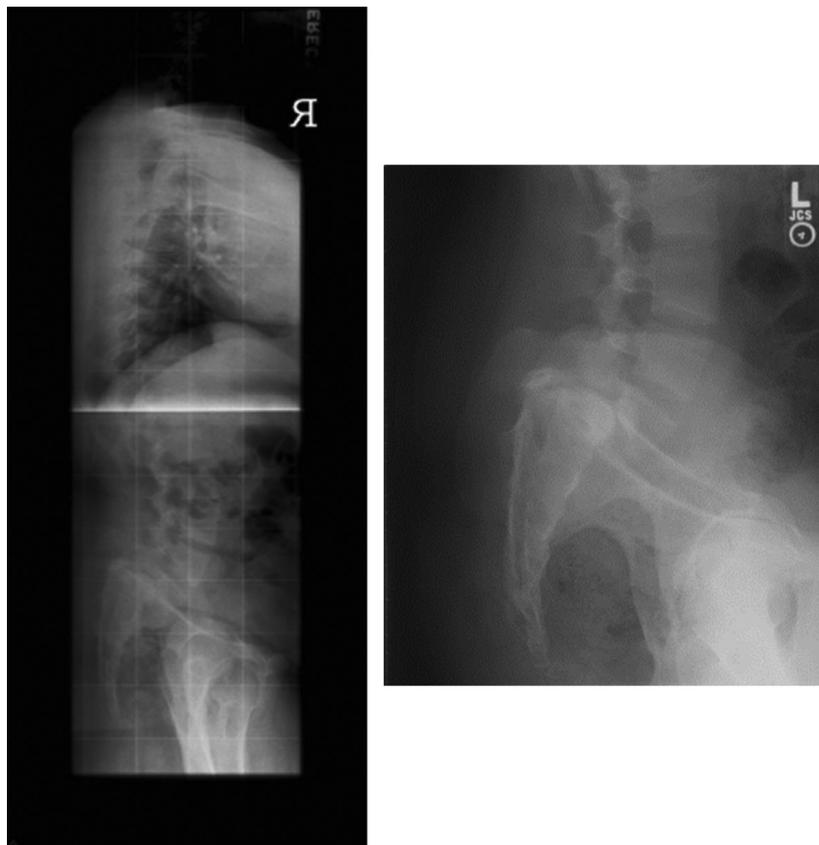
Standing lateral radiographs showing high grade spondylolisthesis at L5-S1.
